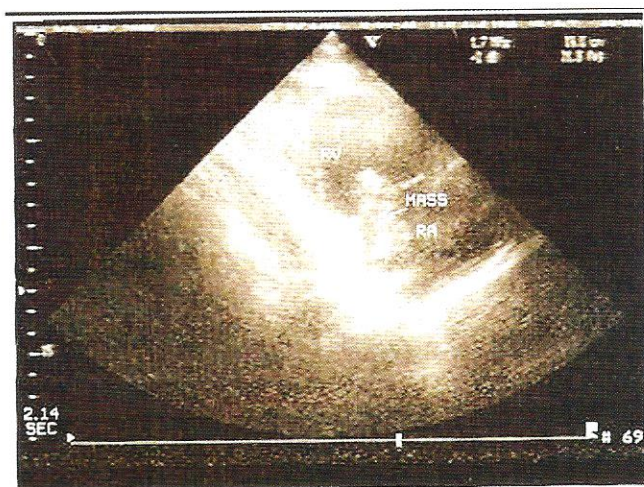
Echocardiographic parasternal view showing right atrial thrombus prolapsing into right ventricle.
